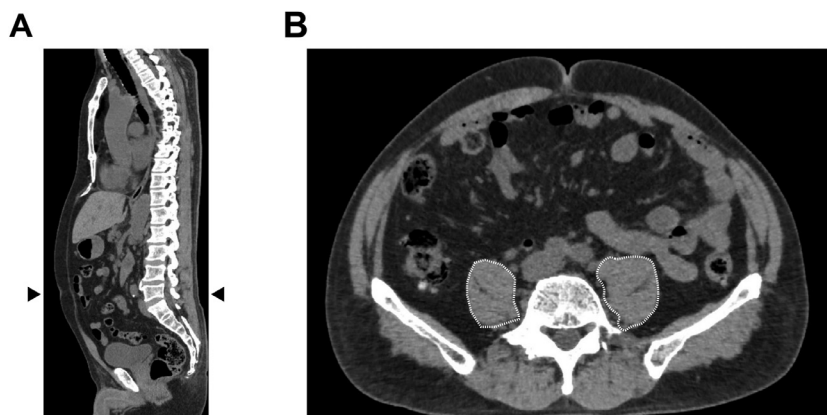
PMI and RD measurement methods. (A) PMI and RD are acquired from CT images at the umbilical level (arrowheads) before allo-HSCT. (B) A sample of a coronal image. Muscle size (PMI) and averaged CT values (RD) in the psoas major muscle (dotted lines) are calculated.
